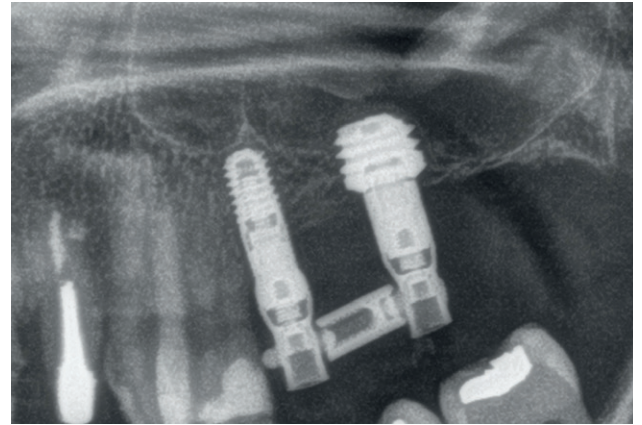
Radiograph showing progressive loading after second-stage implant surgery.
